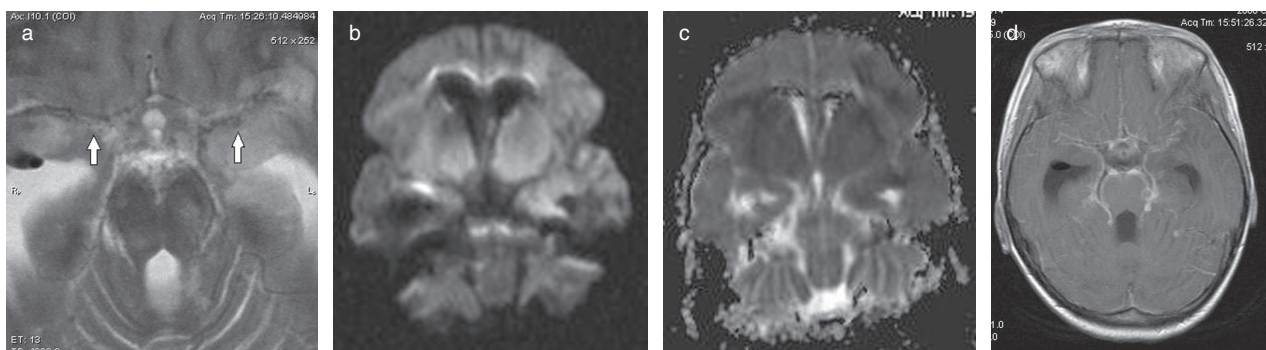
T2 mottling associated with borderzone necrosis at both MCA cisterns. (a) T2-weighted MRI demonstrates a mottled pattern to the MCA vessels possibly related to vasculitis (white arrows). (b) DWI shows increased signal involving the temporal lobes bilaterally corresponding to borderzone necrosis but anterior to the MCA cistern this is difficult to separate out because of a topographic infarct. (c) ADC mapping confirms restricted diffusion at both sites. (d) Gadolinium-enhanced T1 MRI demonstrates moderate basal meningeal enhancement bilaterally at the MCA cisterns. ADC, apparent diffusion coefficient; DWI, diffusion-weighted imaging; MCA, middle cerebral artery.
